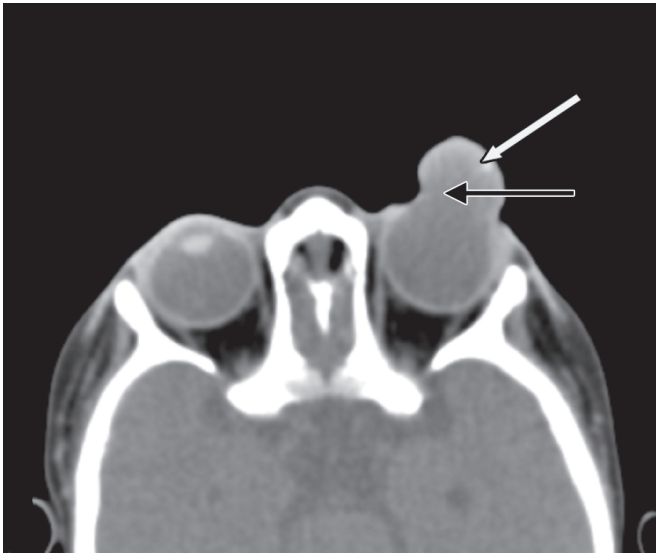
Axial CT orbit showing a focal bulge of the anterior ocular coats (anterior staphyloma) (arrow) with eccentric calcification (block arrow)
